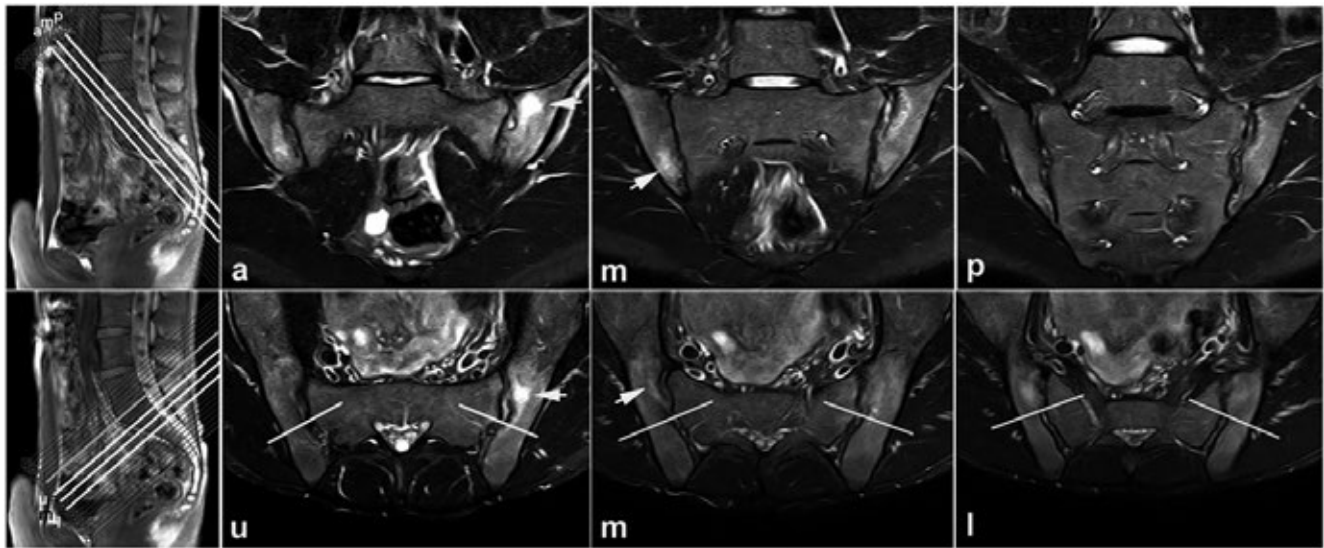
SIJ MRI with semi-coronal (upper row) and semi-axial (lower row) scans. Scout lines on the left panel visualize the orientation of the 2 perpendicular planes. Arrows indicate subchondral BME in corresponding anatomic location on both planes in a patient with axial SpA.
